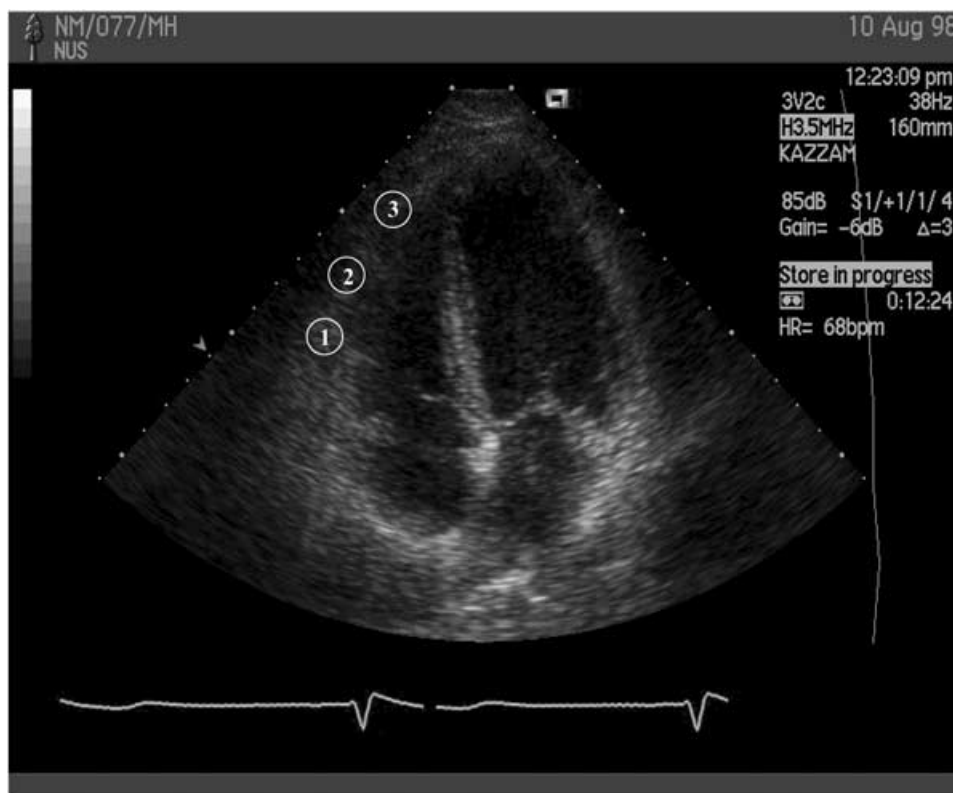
Segmental pulsed Doppler tissue imaging of the right ventricle. 1 = base; 2 = mid-segment; 3 = apical segment.
